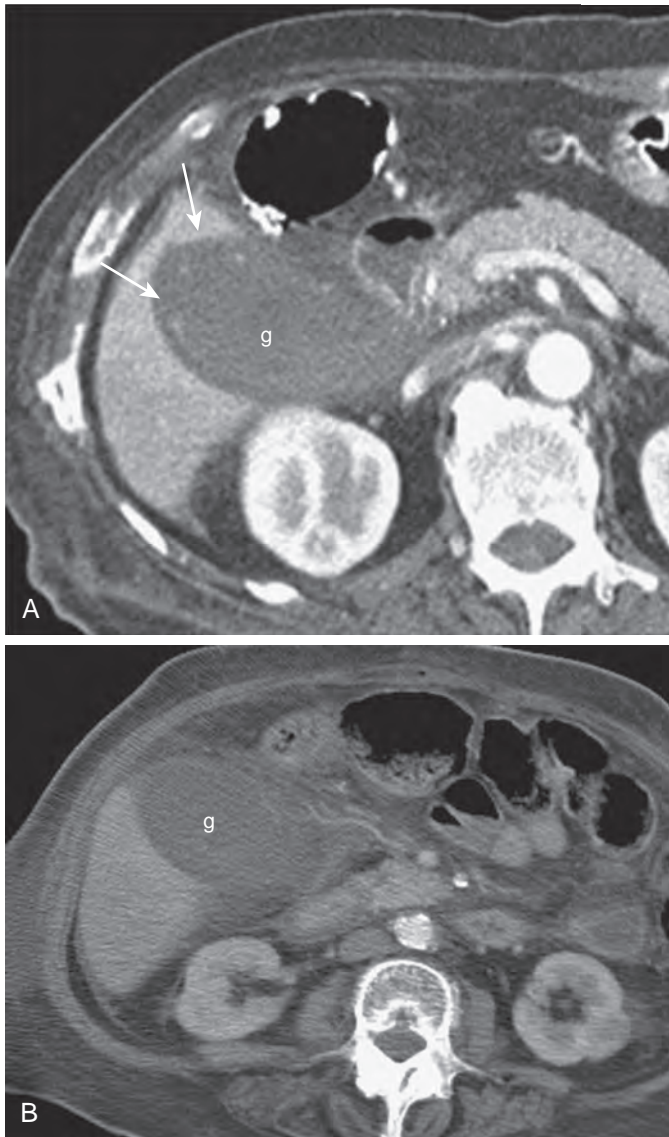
CT of gangrenous cholecystitis: lack of mural contrast enhancement. A. There is apparent discontinuity of the gallbladder wall (arrows) where no mucosal enhancement is noted. *g*, Distended gallbladder. B. Contrast-enhanced CT scan in a second patient demonstrates distended gallbladder (*g*) with extensive pericholecystic inflammatory change. There is no contrast enhancement of gallbladder wall.
